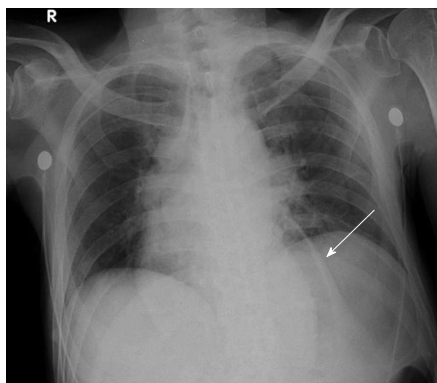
Chest radiograph. Arrow demonstrates air outlining cardiac silhouette. R: Right.
